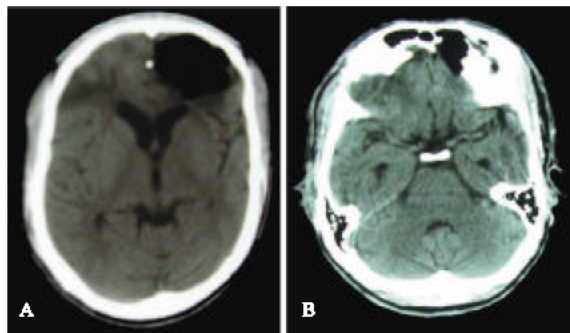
Cranial computed tomography showing rounded air filled cavity (pneumocephalus) in the frontal lobe of the left cerebral hemisphere (A) and a fractured posterior wall of the left frontal sinus (B)
